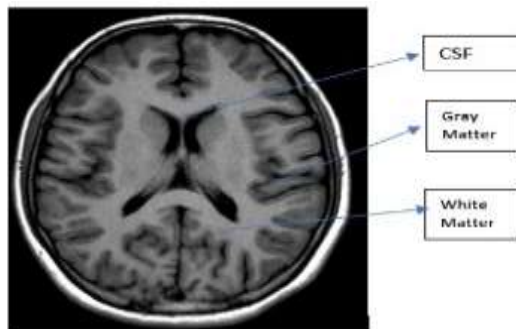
Brain MRI image taken from Kaggle dataset showing three parts of the brain According to the severity, brain tumor is classified into two categories namely benign and malignant (Panda et al, 2019). Benign tumors are less aggressive in the sense that they are slow growing, normal in appearance and have regular boundaries while malignant tumors are aggressive in the sense that they can be life-threatening as their growth is very fast and they have very irregular shape. World health organization (WHO) has placed the malignant tumors into four different grades considering the chemical and physical properties of the tumor (Sharif et al, 2020). The grading criteria is explained in Figure 3 below (Nadeem et al 2020). Figure 1 displays Brain MRI image, Figure 2 shows the progression of brain tumor.
